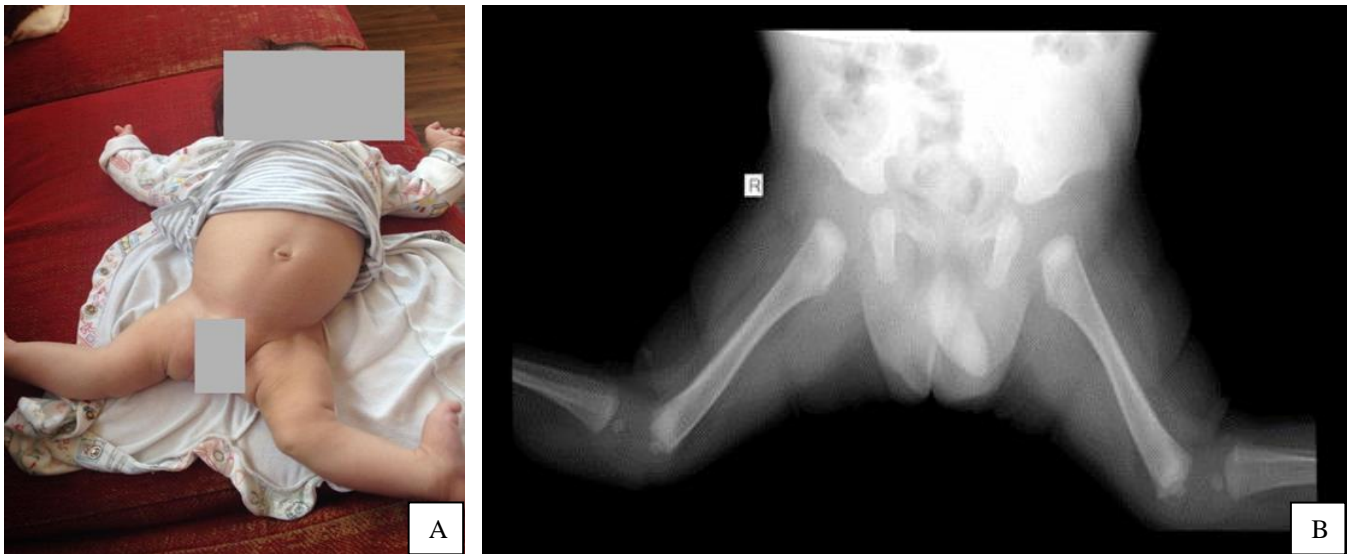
A - Case two, clinical picture at 6 month of age. B - Case two, lateral view on X-ray image of dislocated knees.
